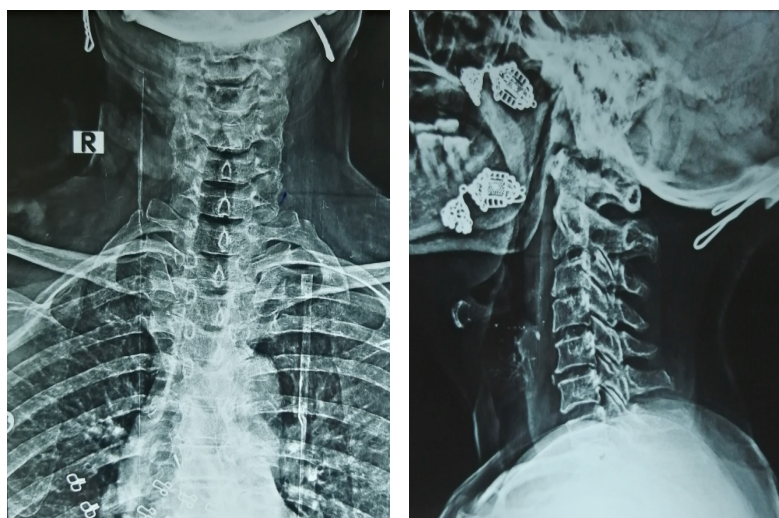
X-ray Cervical Spine (AP and Lateral Views)
